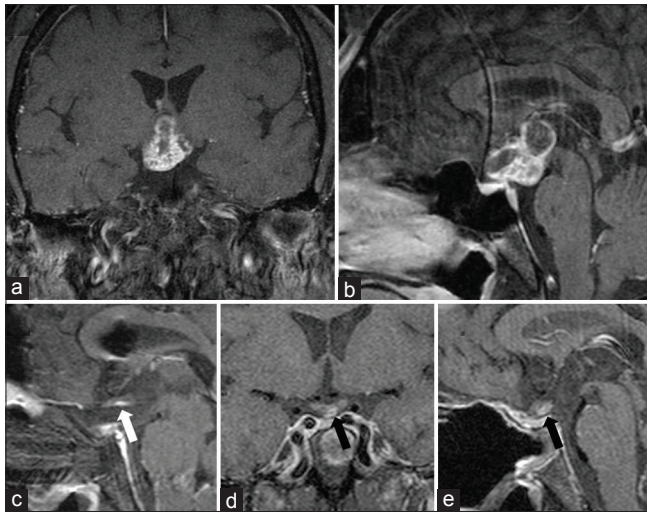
A 52-year-old male who presented with worsening bouts of cold intolerance, 18 kg weight gain over 2 years, fatigue, decreased libido, polyuria, and 6 months of worsening vision. Endocrinological workup revealed central hypothyroidism, hypogonadotropic hypotestosteronism. T1 MRI with gadolinium (a and b) demonstrated a heterogeneously enhancing cystic suprasellar retrochiasmatic mass. The patient underwent an endonasal endoscopic transsellar, transplanum resection of the tumor. The pathology was consistent with craniopharyngioma. The postoperative MRI with gadolinium 1 day after surgery (c) demonstrated near total removal of the tumor with a small amount of tumor purposefully left along the posterior edge of the optic chiasm given its dense adhesions to the optic apparatus (white arrow). MRI with gadolinium 6 months after surgery (d and e) reveals residual tumor along the chiasm that was followed with serial MRIs
